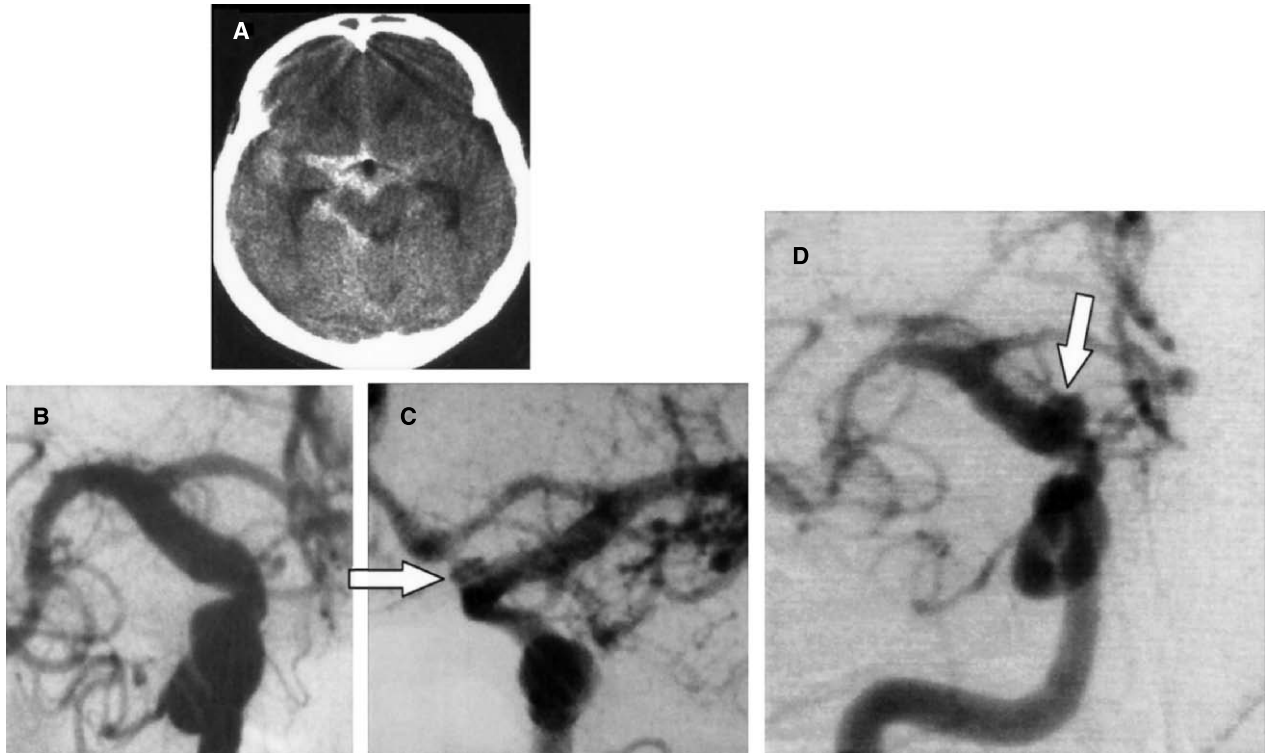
Case 1; 45-year-old housewife with bilateral ICDA: A) Brain CT scan on admission revealed SAH restricted within the right side of the basal and ambient cisterns. B) Right carotid angiogram on the day of admission demonstrated no aneurysm. C) An aneurysmal bulging, which was definable as ICDA, was present on the left C2 portion (arrow). D) Right carotid angiogram taken immediately after the rebleeding on the day 5 revealed a newly developed ICDA in the C2 portion (arrow). See the text for the details
